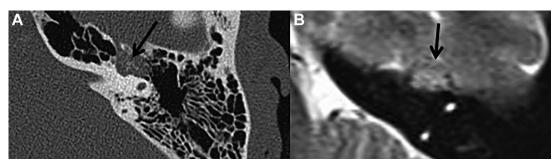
VVM of the facial nerve seen as expansile mass, centered at the GG, with internal trabecular calcifications (arrow) on axial CT (A) and heterogenous appearance on T2WI (B).
